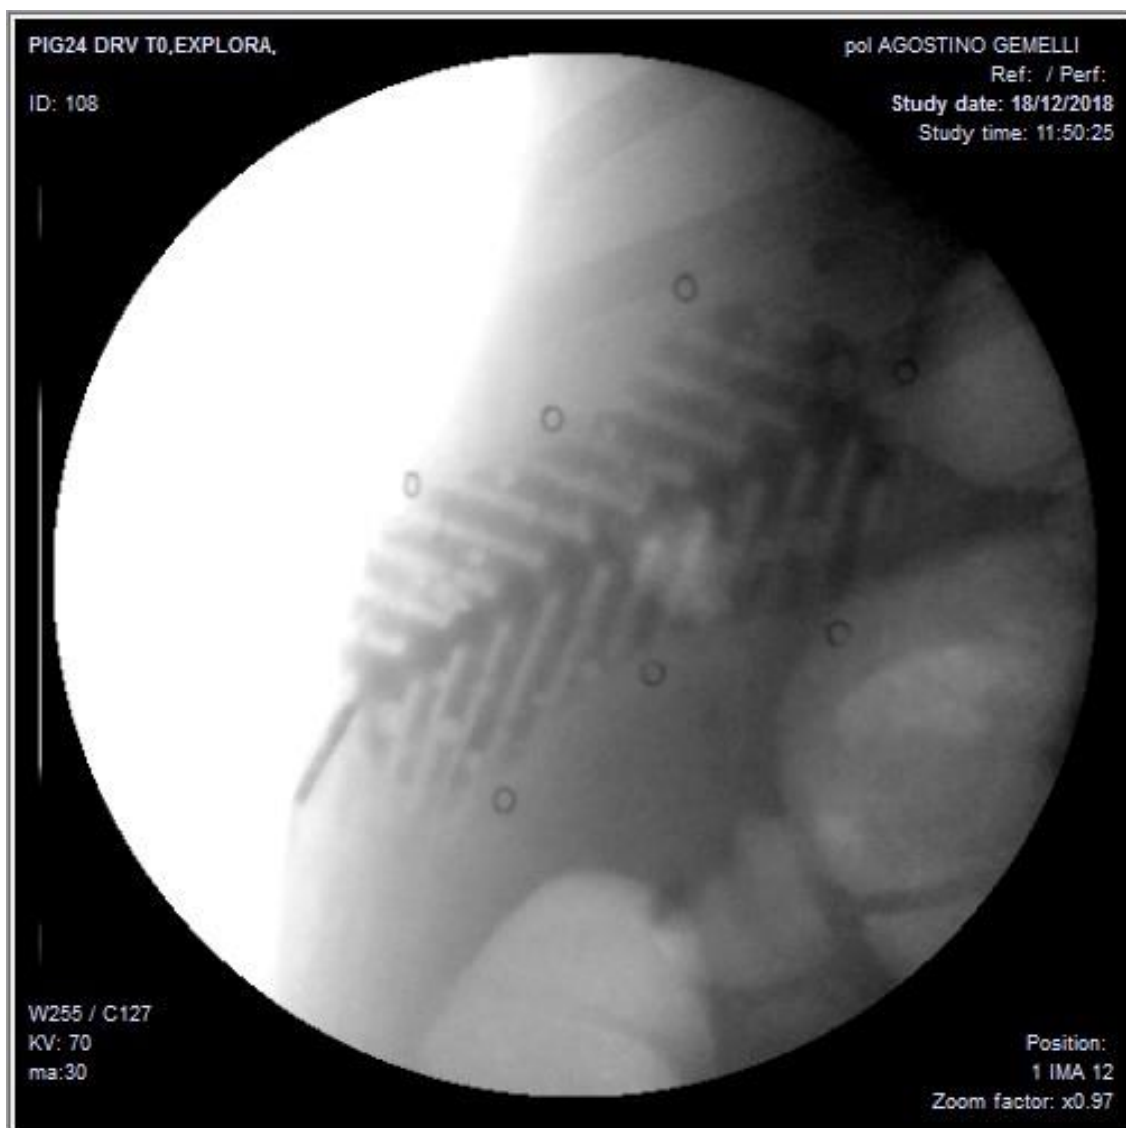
2D x-ray image of a filled 10mL β -shell. RGF2 can be seen as the darker areas throughout the lighter shell structure.
